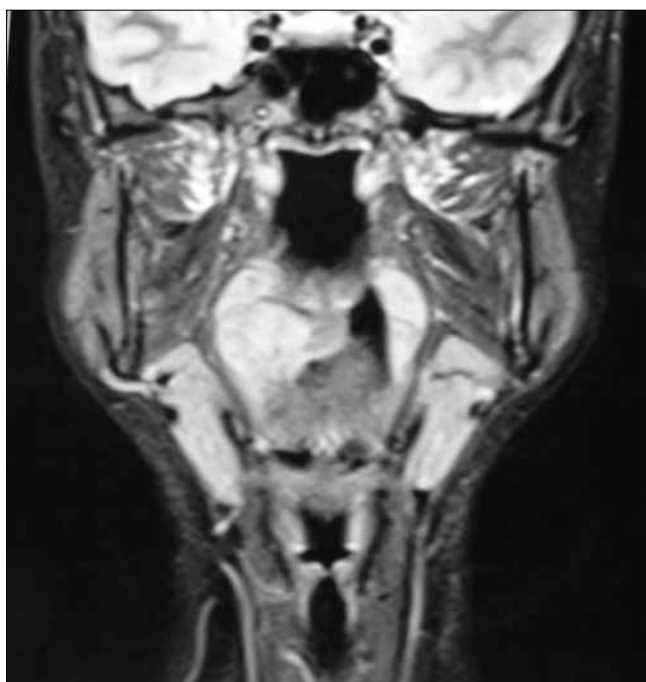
MRI shows an irregular oval-shaped mass, 3 cm in diameter, arising from the right tongue base.
